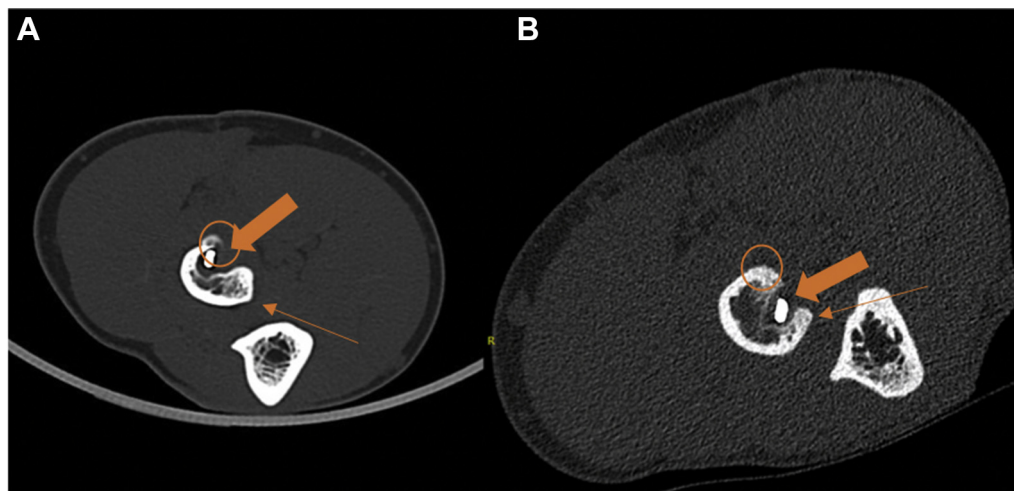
CT images at 6 months. (A) Nonanatomical repair with the drill hole through the fulcrum point of the radial tuberosity. (B) Anatomical repair with preservation of the fulcrum point. —: orientation of the drill hole and site of tendon reinsertion. —: Native tendon insertion site. ○: Cam of the tuberosity acting as a fulcrum point.
